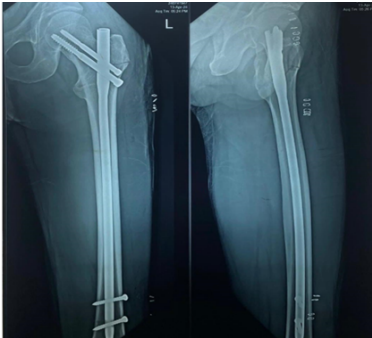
Figure - Post-operative X-ray
